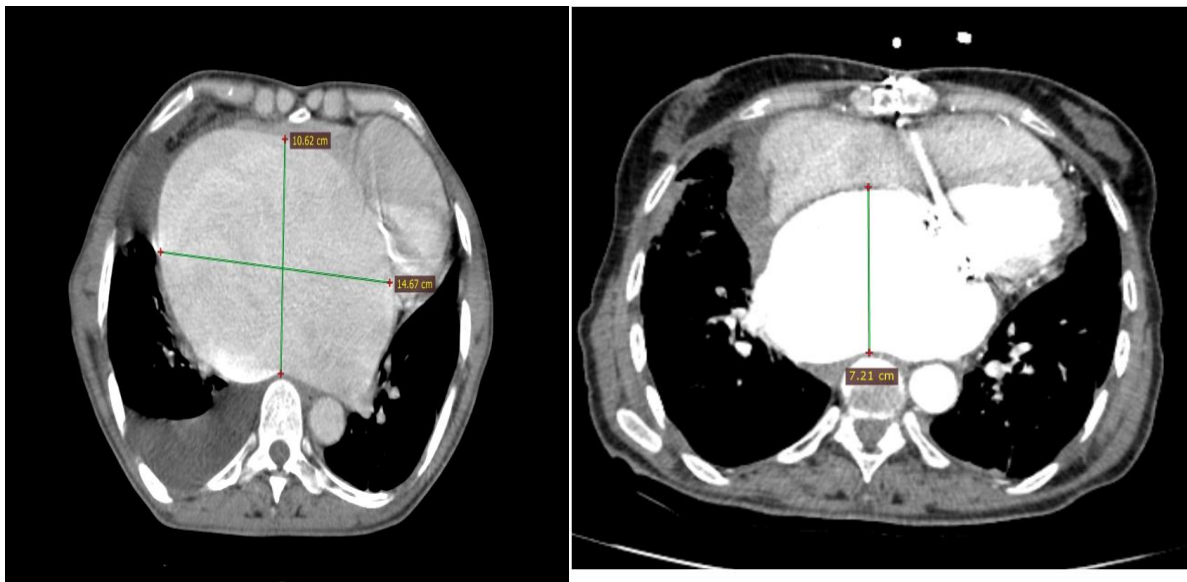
Left: Chest computed tomography showing giant left atrium measuring 10.6 x 14.6 cm with compression of the right middle and lower lobes of lung
